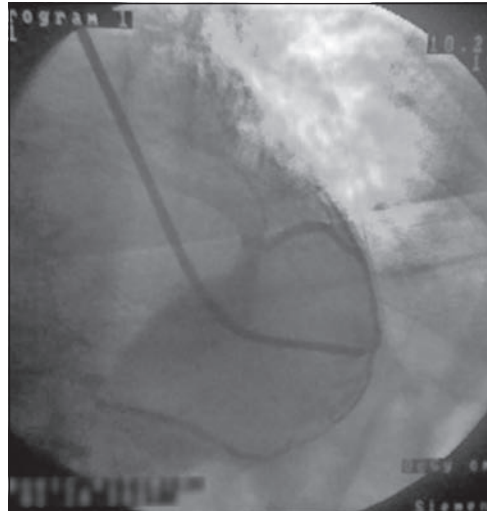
PA chest radiography: venography-coronary sinus (posterior and lateral branch)
